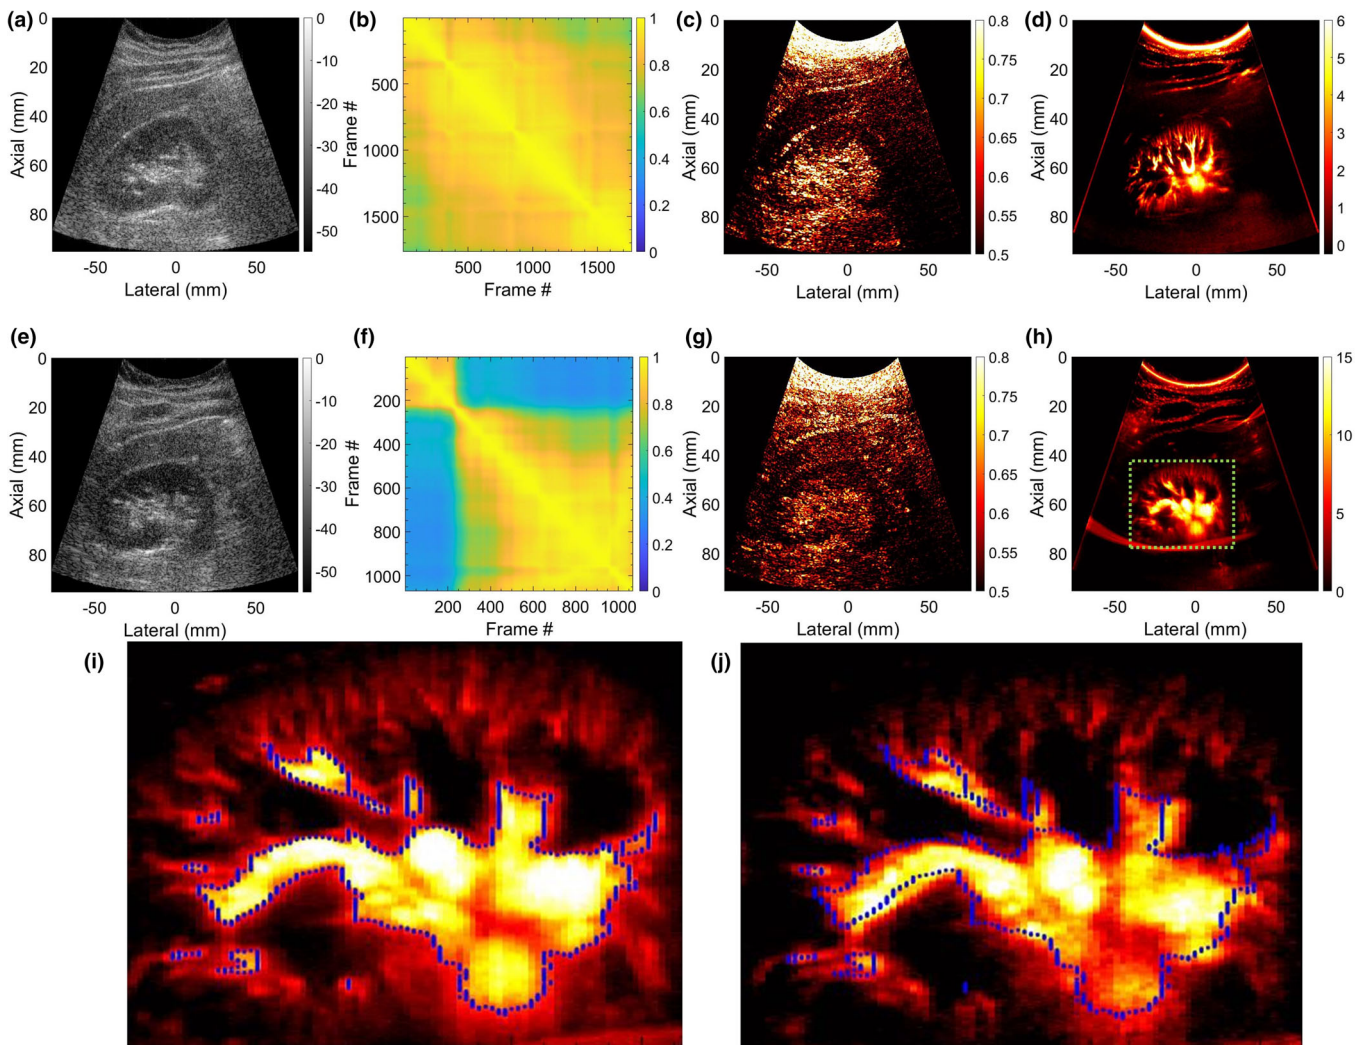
Two representative examples of scan converted renal microvascular blood flow (MBF) imaging using a curved array probe are displayed in Rows 1 and 2, respectively. (a,e) display the scan converted sonograms of the kidney. (b,f) display the spatiotemporal correlation matrix images quantifying temporal coherency of the Doppler ensemble with respect to the pixels corresponding to the renal area. (c,g) display the scan converted local spatiotemporal correlation images quantifying spatial coherency of the Doppler ensemble across the entire imaging plane. (d,h) display the respective scan converted renal microvascular blood flow (MBF) images. (i,j) correspond to MBF images of the second renal example (e-h), estimated by integrating frames (236-2064,1-235) of the clutter-filtered Doppler ensemble, respectively. The blue outline display the lack of registration between the MBF images (i,j), even though estimated from the same ensemble. [Color figure can be viewed at wileyonlinelibrary.com]
